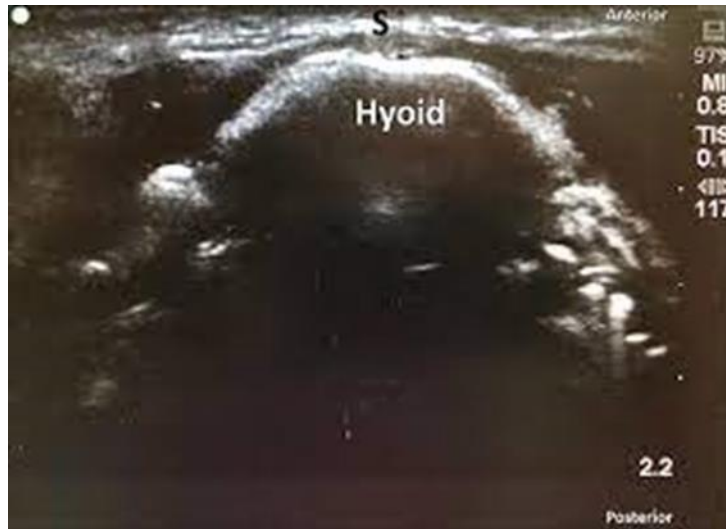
Ultrasonographic image of hyoid bone
